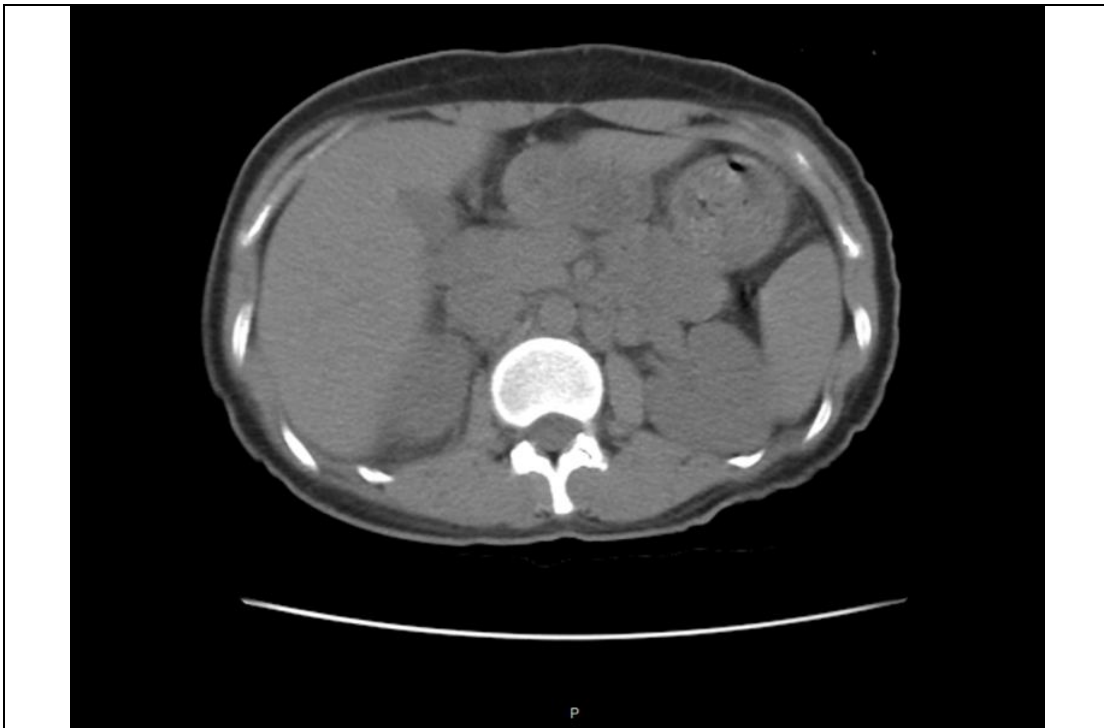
Abdominal CT prior to ceftriaxone treatment showing unremarkable gallbladder and bile ducts
